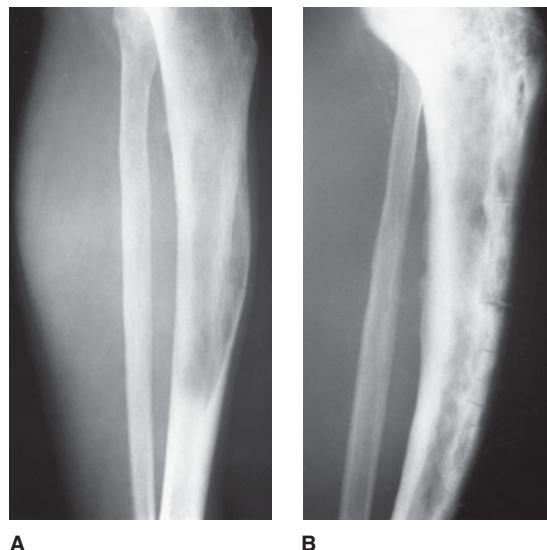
Early and late radiographs of Paget's disease of the tibia, taken when the patient was 45 years old (A) and 65 years old (B). (Reprinted, with permission, from Skinner HB. *Current Diagnosis & Treatment in Orthopedics*, 3rd ed. New York: McGraw-Hill, 2003: Fig. 6-89.)
